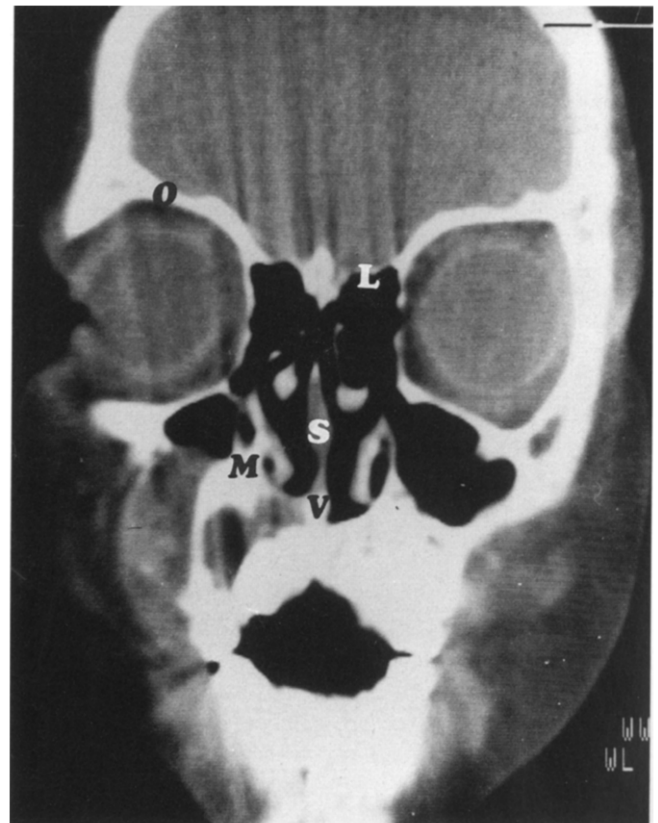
CT of a 6-year-old infant. L, bony lamina cribrosa; S, nasal septum; V, vomer; M, maxilla; O, orbital roof. Note osseous continuity of the base of the skull. (Philips Tomoscan 350, section thickness 1.5 mm)
